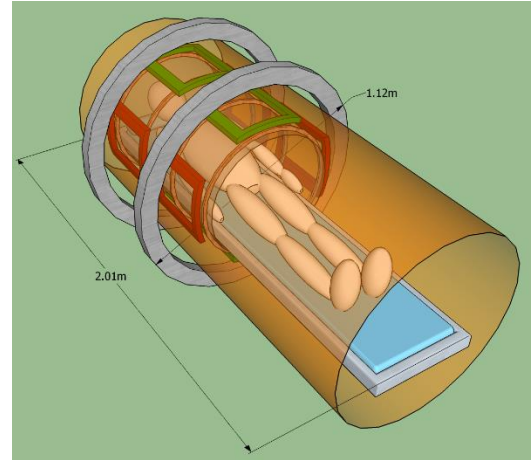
System design for whole-body SPECT-CT containing Helmholtz coils (gray), gradient coils (red and green), a cylindrical γ -ray detector array (orange), and a patient table. Note that for clarity only a top portion of MR components are shown for the whole-body SPECT-CT system rendering.
